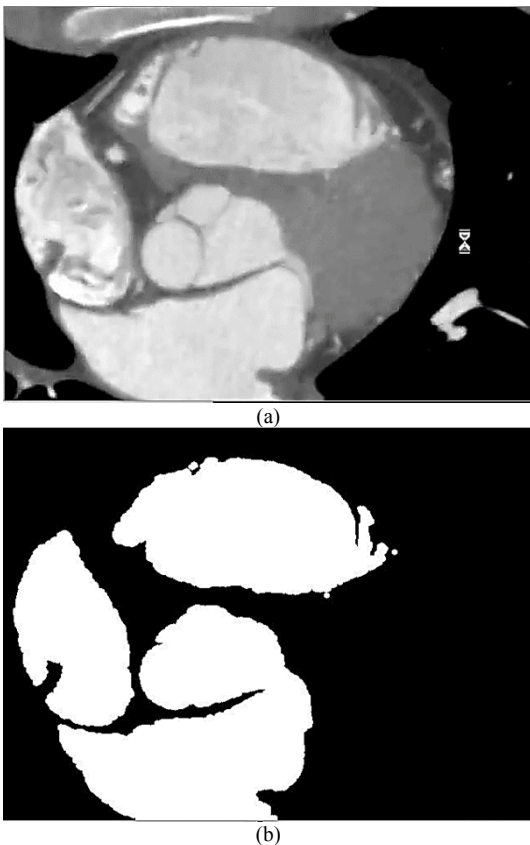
(a) The original CT-scan image (b) Preprocessing result
